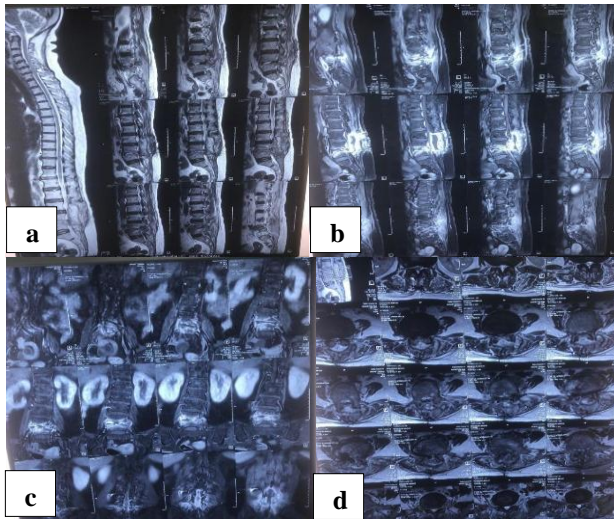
(a-d): MRI images of post-operative discitis.
